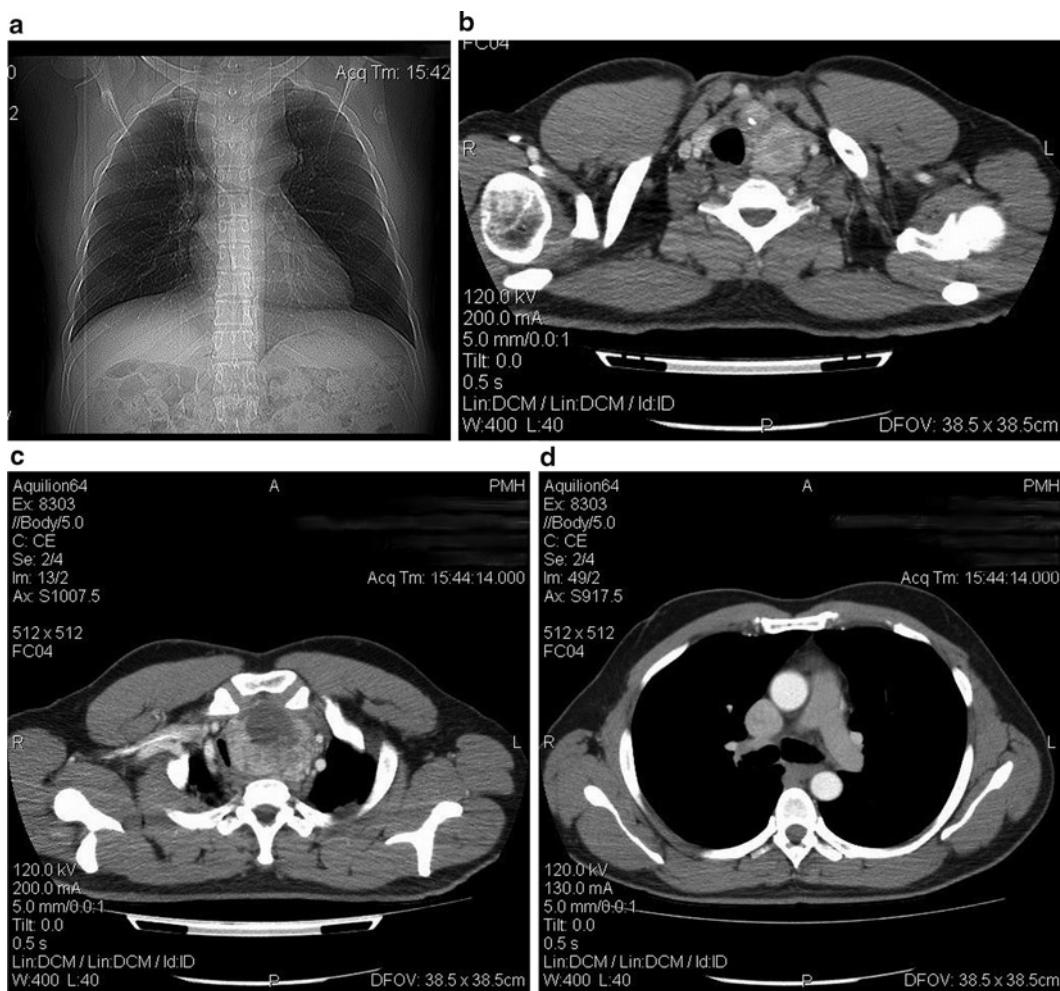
(a) Chest X-ray of a 55-year-old female patient with mid-thoracic tracheal compression from an intrathoracic goiter. It shows trachea compression and deviation to the right. (b) CT scan of the same patient with mid-thoracic tracheal compression from an intrathoracic goiter. It shows the mediastinal mass pushing the trachea to the right. (c) CT scan of the patient with mid-thoracic tracheal compression from an intrathoracic goiter. It shows the trachea compressed to almost a slit by the mass. (d) CT scan of the patient with mid-thoracic tracheal compression from an intrathoracic goiter. It shows right and left main stem bronchi, relatively free from compressive effects. This patient was intubated distal to the stenosis awake.
